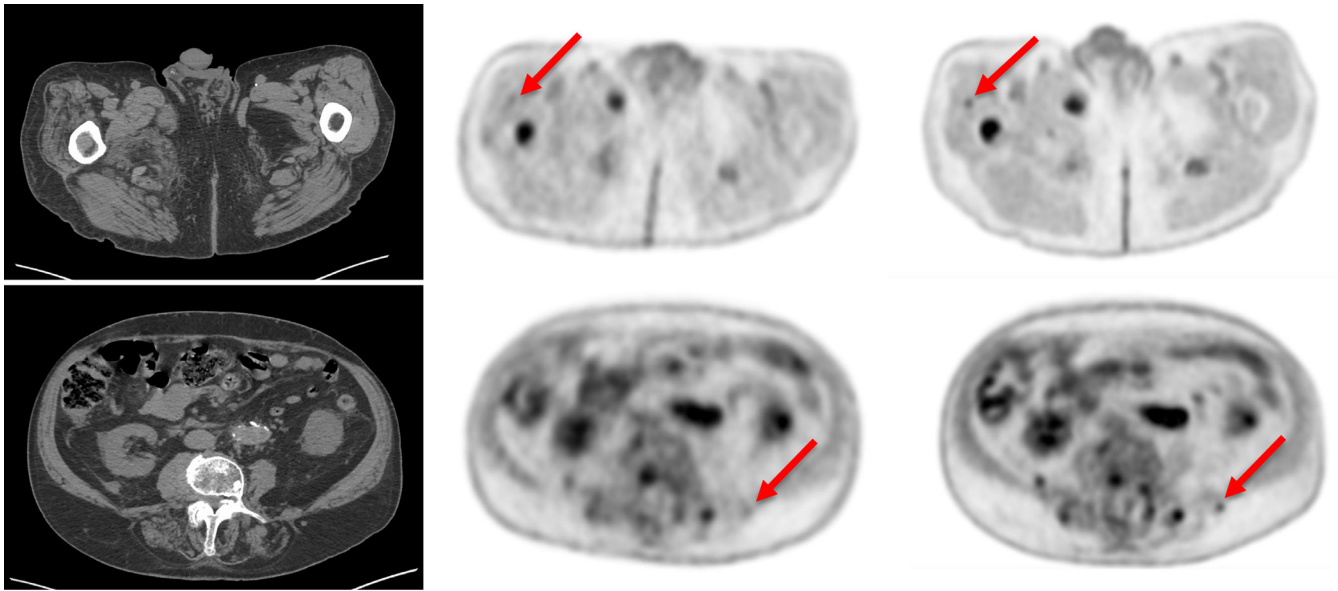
Millimetric metastases (red arrows) in a Patient with stage IV lung cancer scanned on uExplorer (right column) and a conventional scanner (middle column) on the same day with ^{18}F -FDG. Note the higher level of detail provided by uEXPLORER images, given its increased sensitivity compared to conventional scanners.
